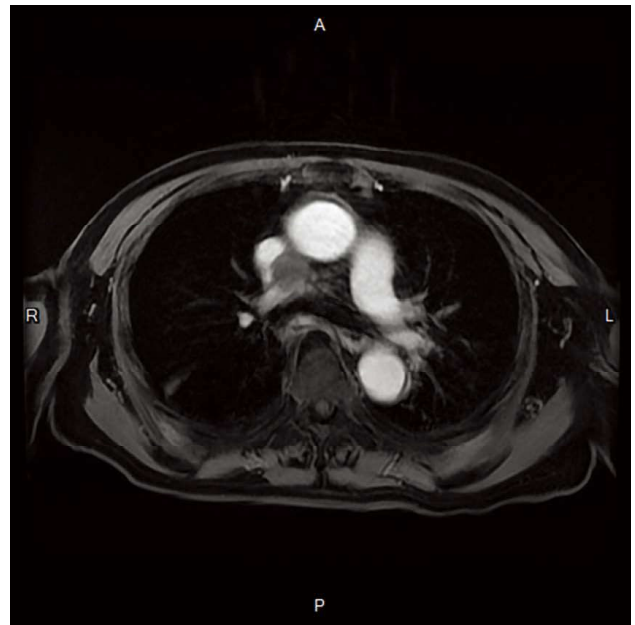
Chest magnetic resonance imaging showed an enlarged lymph node with necrosis in the pretracheal retrocaval (PTRC) region.
